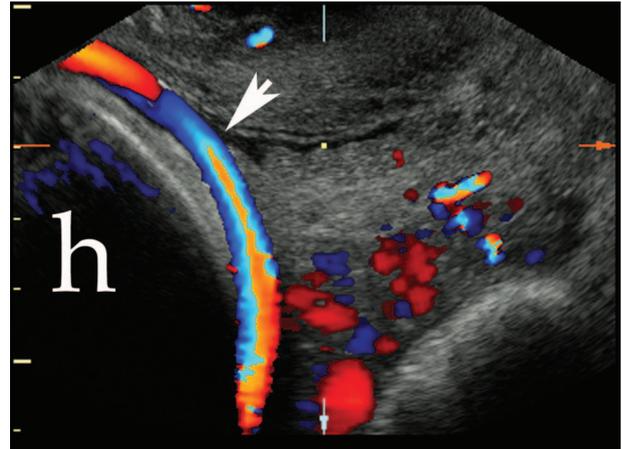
Vasa previa. Transvaginal ultrasonography with color Doppler showing the fetal vessels running over internal os of the cervix (*arrow*). *h*, fetal head. Oyelese. *Placenta Previa, Accreta, and Vasa Previa*. *Obstet Gynecol* 2006.
